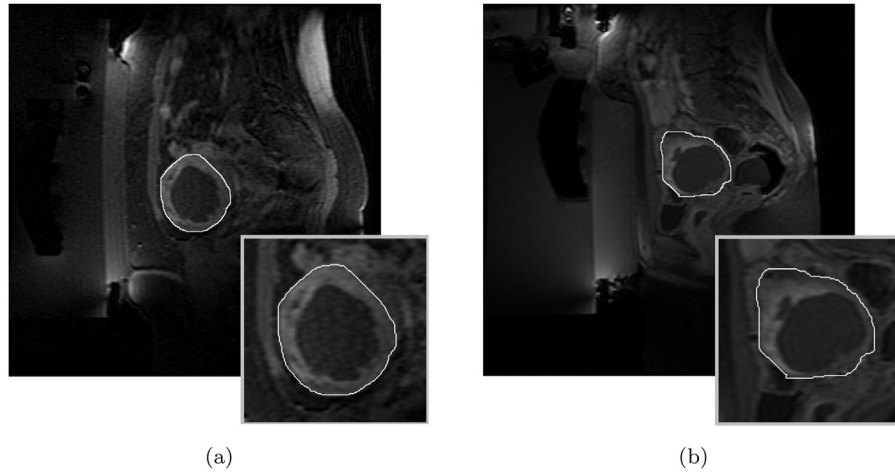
Examples of MR images. The ROI bounding region (i.e., the delineated uterus region), which includes the actual ROI (i.e., the uterine fibroid region), is highlighted with a white contour. The image regions including the ROIs, zoomed at the bottom right of each sub-figure, are characterized by nearly bimodal histograms.
